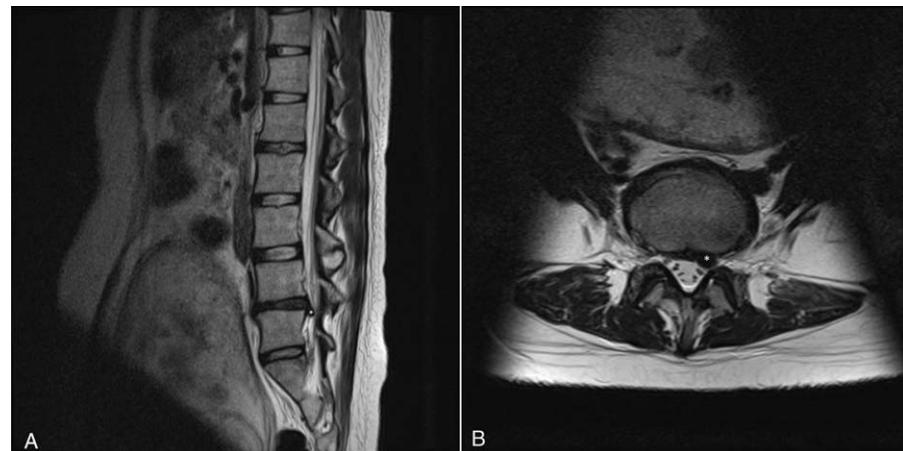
Preoperative MRI shows a herniated disc at L4-5 level (asterisk) and a definitively compressed nerve root (arrowhead). (A) Sagittal T2-weighted image. (B) Axial T2-weighted image. Images were taken at 20-week gestation. MRI indicates magnetic resonance imaging.
